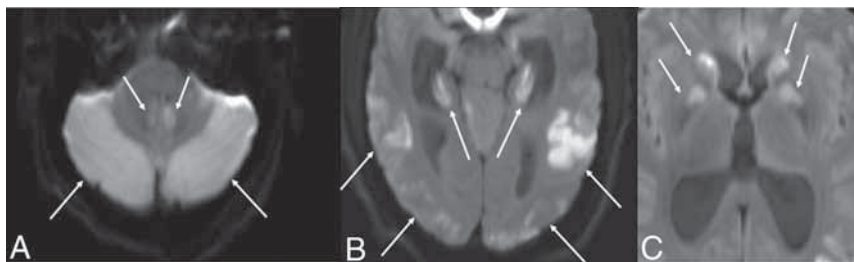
MR DWI from patient 2, six hours after presentation, shows diffusion restriction in the cerebellar hemispheres (white arrows, A), hippocampi and temporo-occipital cortex (white arrows, B), and basal ganglia (white arrows, C). The ADC map is not shown.
